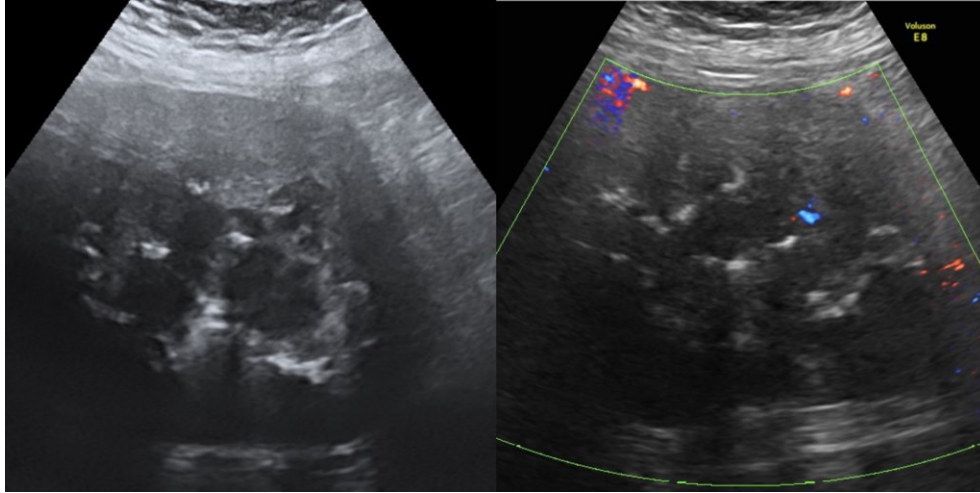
Uterine myoma necrosis, heterogeneous mass with hypoechoic/anechoic cystic areas secondary to necrosis and no color Doppler flow
